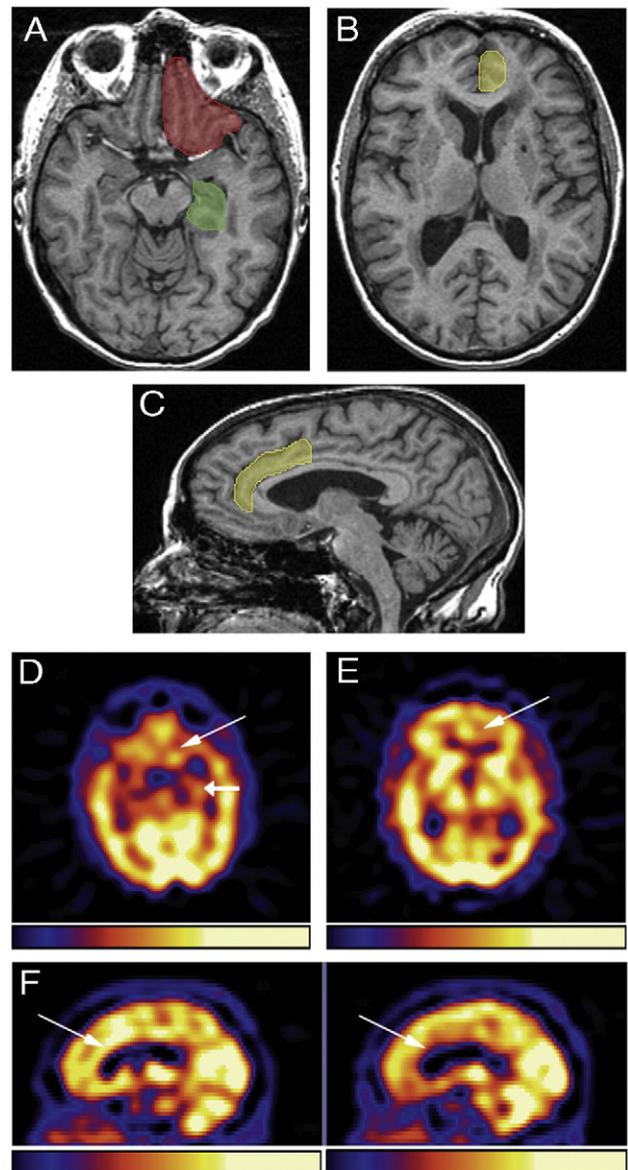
Panel A: Representative coregistered MRI scan indicating the location of the L-OFC (red) and L-MTC-m (green) ROIs on SPECT. Panels B and C: Representative coregistered MRI scans (axial, B; sagittal, C) indicating the location of the L-ACC ROI on SPECT. Panel D: Representative SPECT scan from a patient with appetite loss, indicating hypoperfusion to the L-OFC and relative sparing of perfusion to the L-MTC-m. Panel E: Axial view of a representative SPECT scan from a patient with appetite loss, indicating hypoperfusion to the L-ACC. Panel F: Sagittal views of a representative SPECT scan from a patient with appetite loss, indicating hypoperfusion to the L-ACC (right panel), as compared to the R-ACC (left panel).
